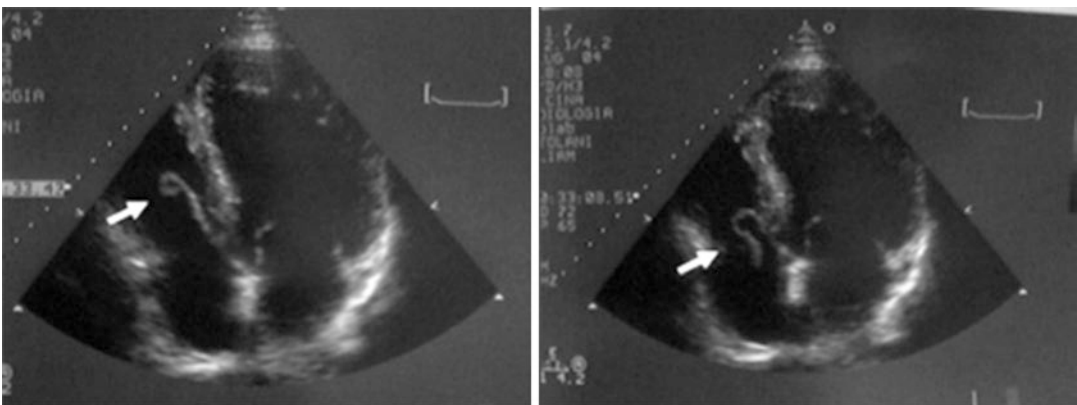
Tricuspid valve vegetation viewed on trans-thoracic echocardiography. Chesi G, Colli A, Mestres CA, Gambarati G, Boni F, Gherli T. Multiresistant-MRSA tricuspid valve infective endocarditis with ancient osteomyelitis locus. *BMC Infect Dis* 2006; 6(1):124. Copyright © 2006 Chesi et al.; licensee BioMed Central Ltd. This is an
